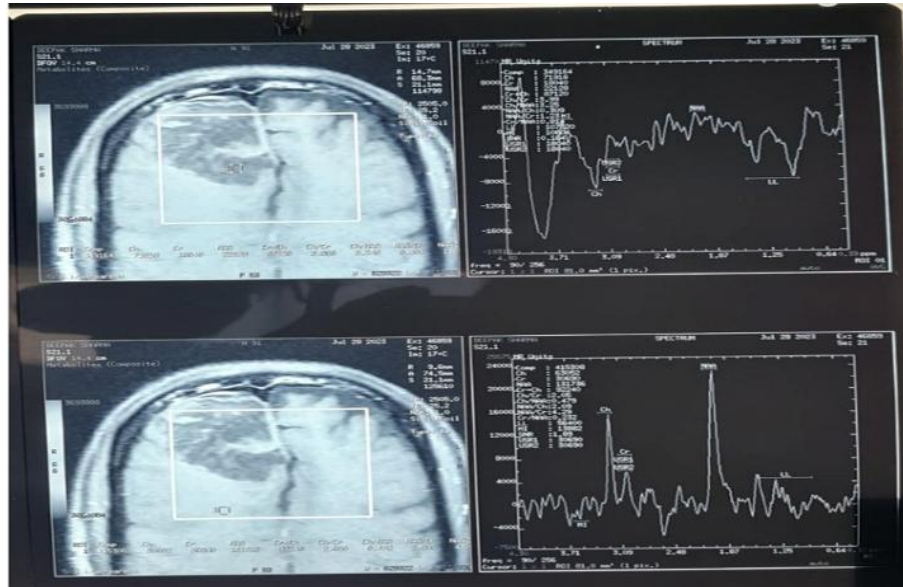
MRI image showing lesion in right frontal lobe.
